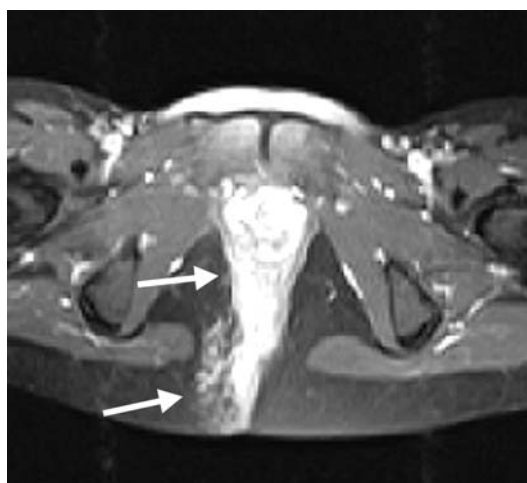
Post-contrast axial fat-saturated T1-weighted MR image shows a marked enhancement of the inflammatory changes (*arrow*) infiltrating both sphincter muscles and the vagina.
